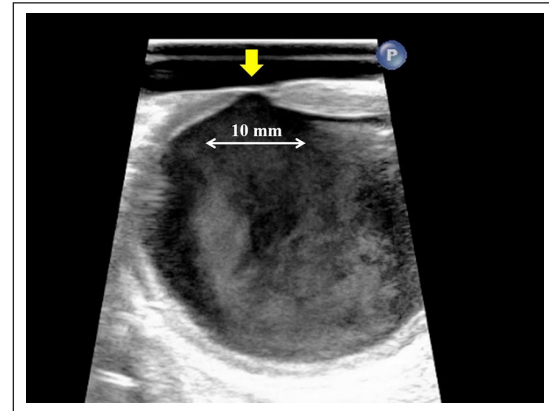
Epaortic echocardiography demonstrates intimal ulceration (arrow) with subsequent penetration into the media and adventitia. However, neither aortic dissection nor intramural hematoma was observed adjacent to the ulcer.
